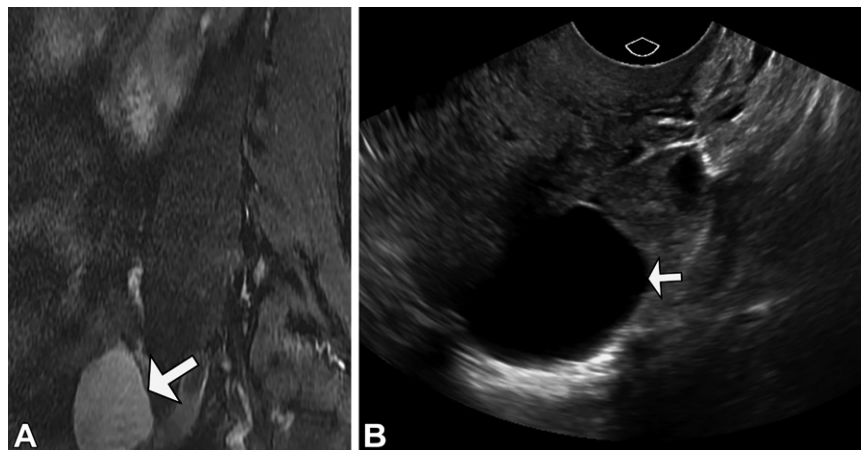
Incompletely evaluated adnexal cyst at lumbar spine MRI in a postmenopausal patient that requires additional characterization. (A) Sagittal fat-suppressed T2-weighted MR image from a lumbar spine examination shows a partially visualized 4-cm left adnexal cystic mass (arrow). This is the last image in the sequence, and portions of the mass are excluded from the field of view. (B) Subsequent US image shows a simple unilocular cyst (arrow).
